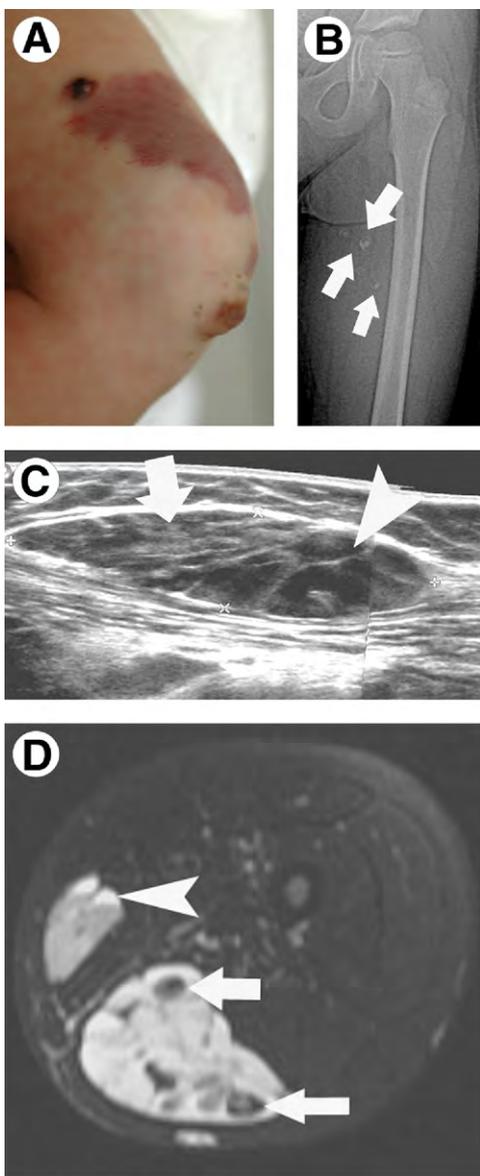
Venolymphatic malformation in a 6-year-old female with leg swelling for 2 months. (A) Photograph of the lower extremity shows an ill-defined purple plaque with nodules. (B) Plain radiograph demonstrates several focal phleboliths (arrows). (C) Sonogram of the leg shows mixed echogenic, partially cystic (arrow head), and partially solid mass (arrow). (D) Axial T2-weighted fat-suppressed image reveals a multispacial multicystic mass with fluid levels (arrow head) and phleboliths (arrows).
